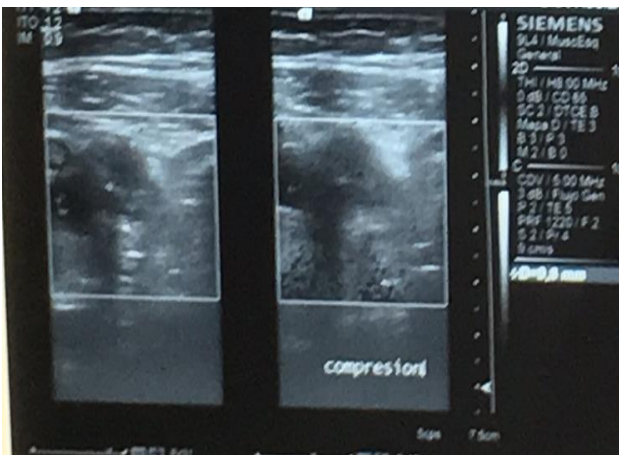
Pelvic ultrasonography that shows no changes on appendicular diameter upon compression, suggesting appendicitis.
